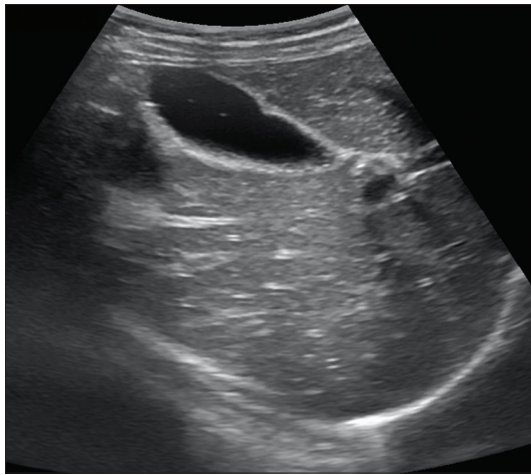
Ultrasonography showing no significant abnormalities, including no evidence of gallbladder sludge or pseudolithiasis
